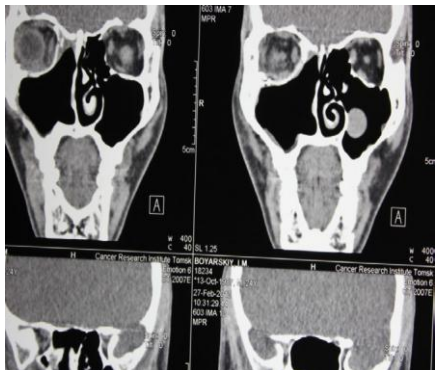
Postoperative CT scan of the patient. The implant position fits healthy bone structures
